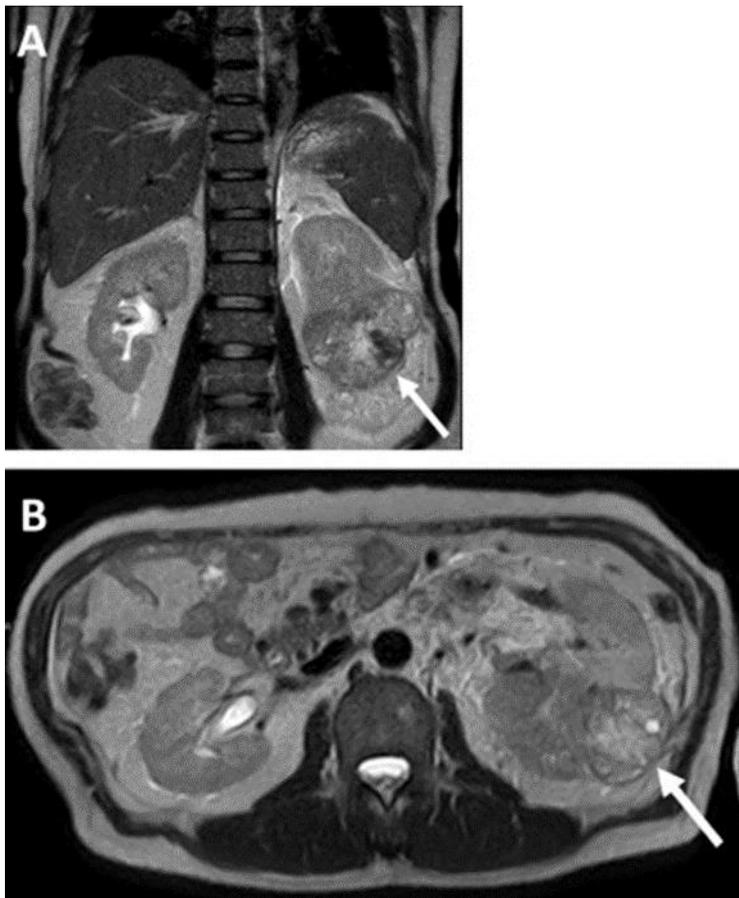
MRI of left-sided dorso-caudal renal cell carcinoma A axial, B sagittal
